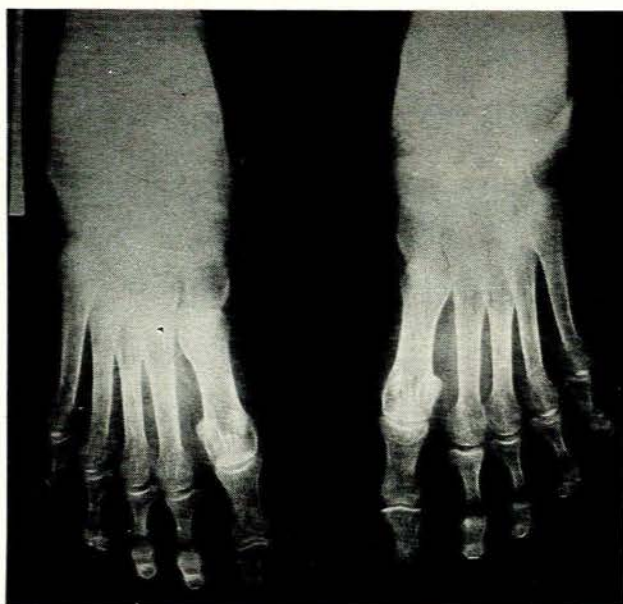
Radiograph of the feet of an affected female. The maximum deviation occurs at the proximal interphalangeal joint.
